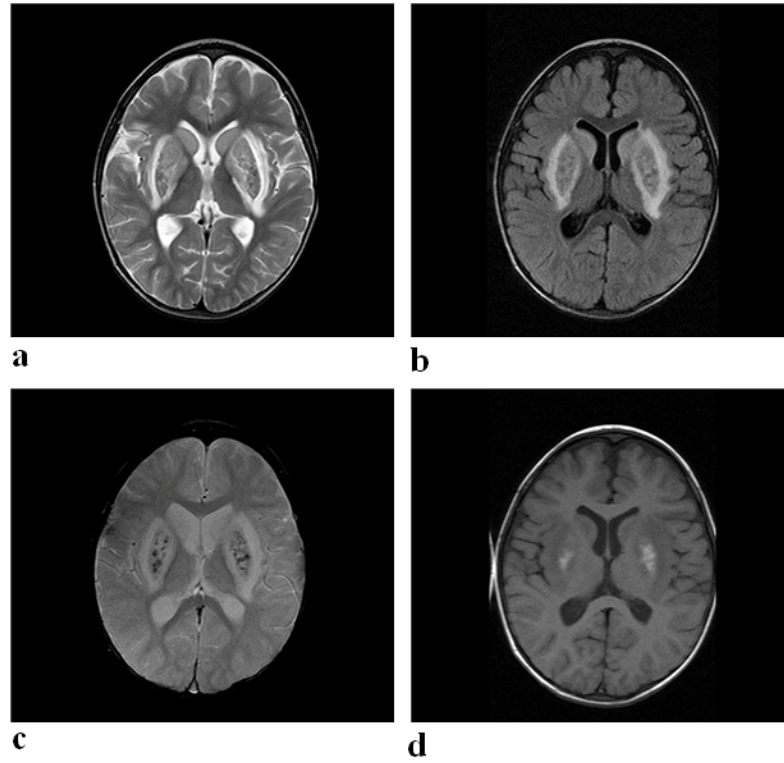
A-D: An area of hemorrhagic damage is observed in bilateral lentiform nuclei with central heterogeneous hypointense and peripheral hyperintense appearance on T2-weighted (Fig. 1A), Flair (Fig. 1B), and GRE (Fig 1C) sequences, and central hyperintense and peripheral hypointense appearance on T1-weighted (Fig. 1D) axial images. Both caudate nuclei showed increased signal intensity on T2-weighted GRE and FLAIR sequences and decreased signal intensity on T1-weighted sequences suggestive of damage (Figs. 1A-D).
